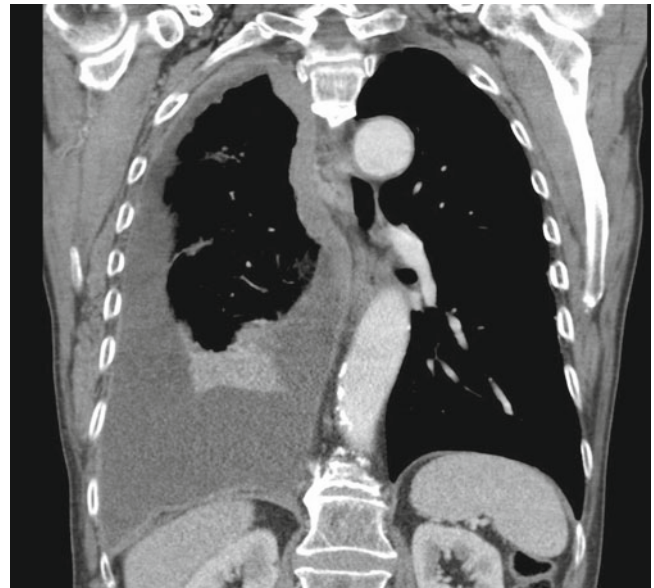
CT scan of mesothelioma on the *right side*. The right lung is surrounded by pleural tumour, and the *middle and lower lobe* are compressed by pleural effusion
